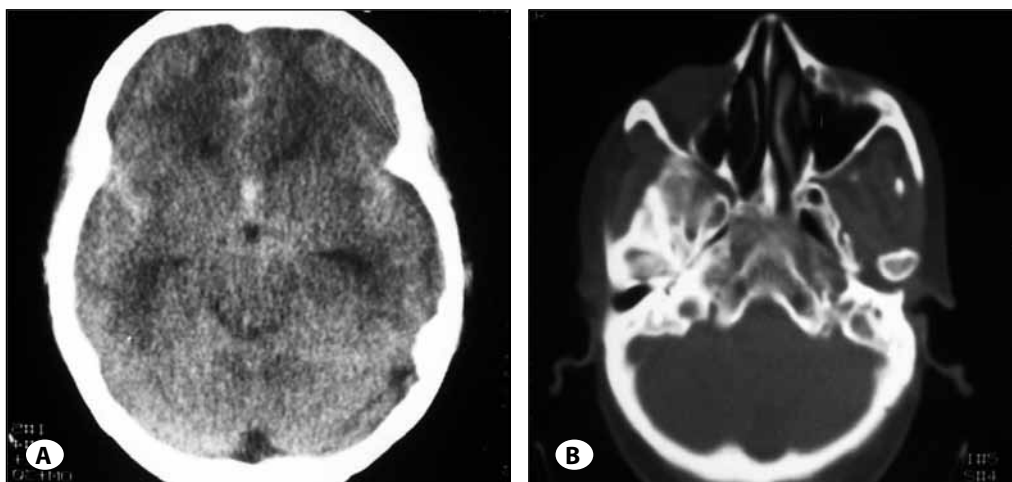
A) Axial CT scan brain window showing subarachnoid hemorrhage in the inter hemispheric and sylvian fissure. B) Axial CT scan bone window showing the absence of the right carotid canal.
